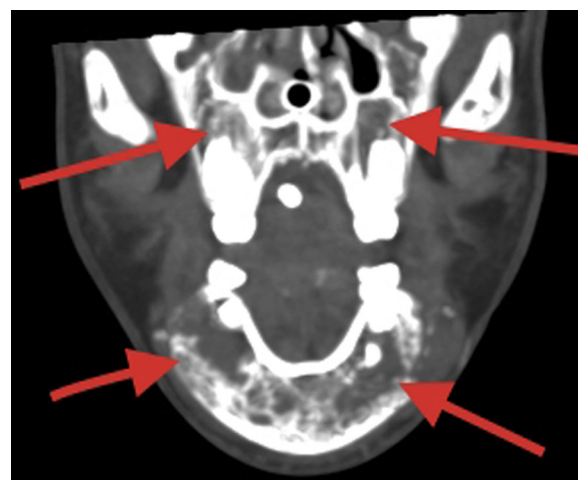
The angio-CT coronal view of the mandibular and maxillary lesions.
